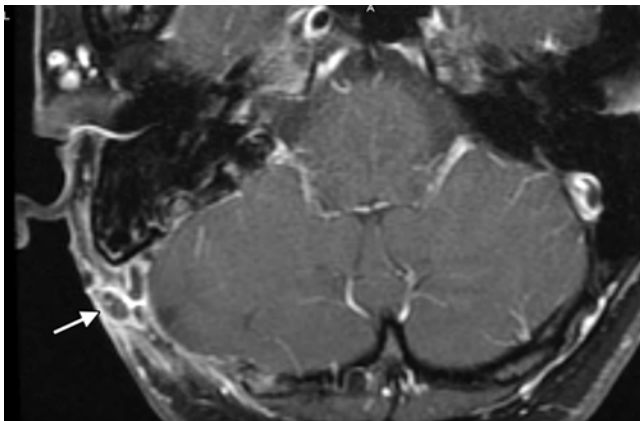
Wound infection. Axial postcontrast T1-weighted MRI study showing rim-enhancing fluid collections in the subcutaneous tissues overlying the right retrosigmoid craniotomy and in the epidural space (arrow).
